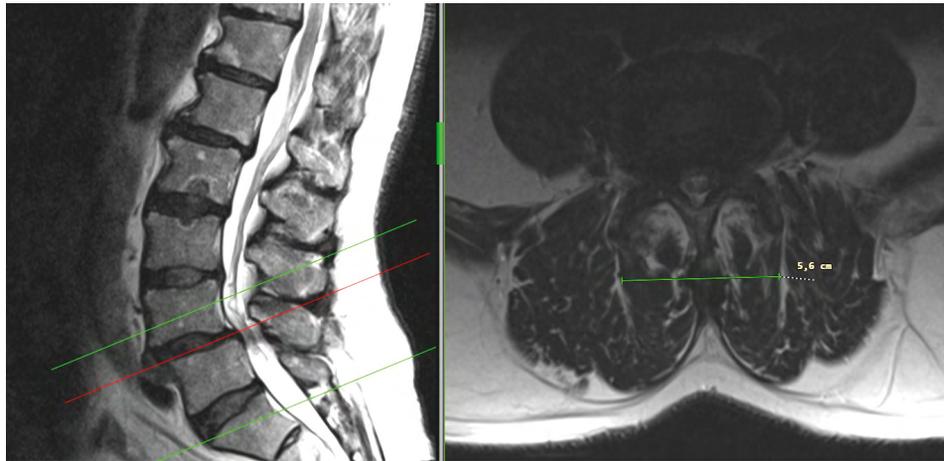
Preoperative T2-weighted MRI scan of a patient with L4/5 spondylolisthesis – measuring bilateral width of multifidus muscles in the operated segment
